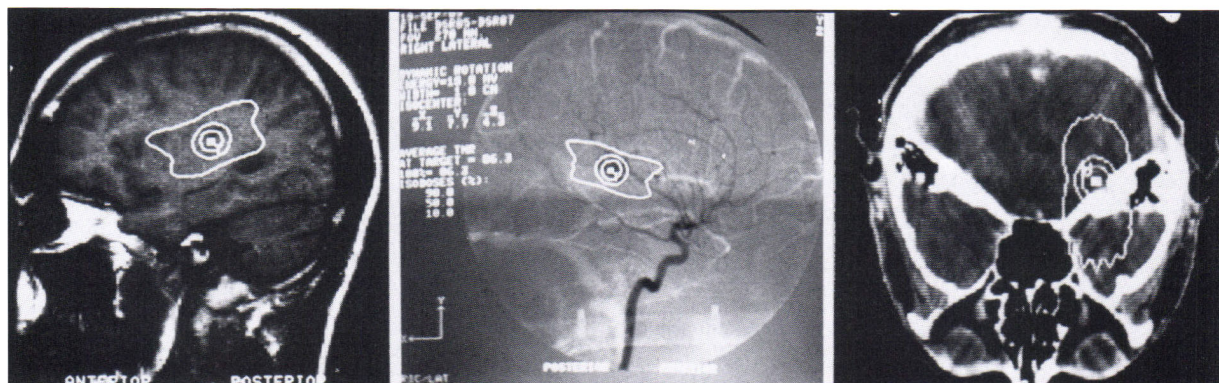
Examples of dose distributions (90, 50, and 10% isodose lines) for the linac-based dynamic rotational technique displayed in the sagittal planes of magnetic resonance imaging and digital subtraction angiography, and the transverse plane of computerized tomography.
